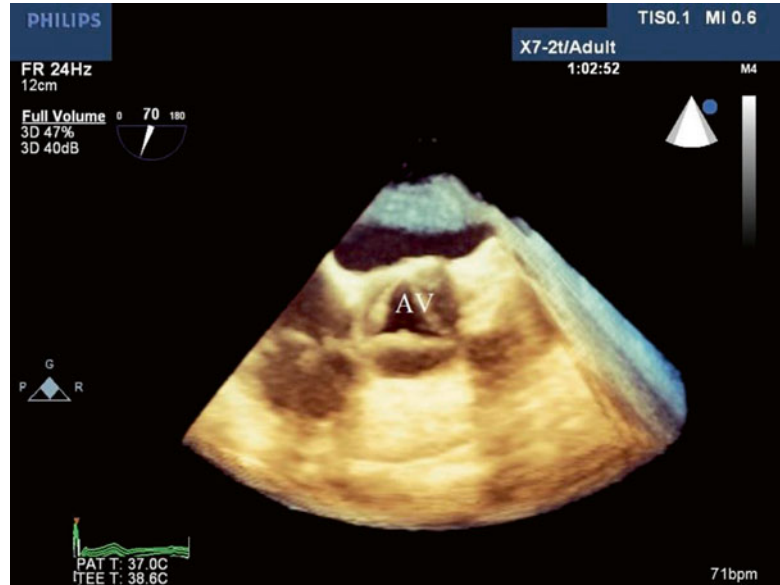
Normal tricuspid aortic valve by three-dimensional transesophageal echocardiography. AV aortic valve
